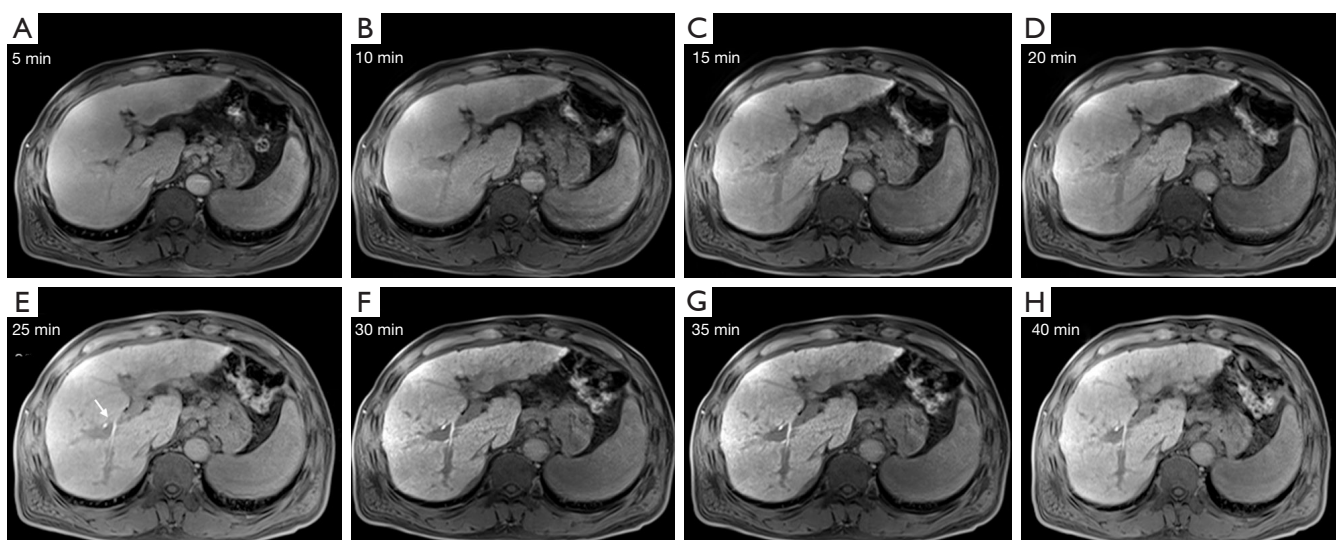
A male cirrhosis patient (CP B), 60 years old, with eight phases of the HCP imaged from 5 to 40 min (A-H) after the administration of the Gd-EOB-DTPA. Two radiologists with 8 and 10 years of experience in abdominal MRI diagnosis identified 25 min (E) as the initial intrahepatic bile duct visualization (white arrow) and so 30 min (F) as the HCP_{proposed}. Two months later, the same two radiologists identified 30 min (F) and 35 min (G) as the HCP_{EC}, respectively, then the third radiologist arbitrated the HCP at 35 min as the HCP_{EC}. CP, Child-Pugh; HCP, hepatocyte phase; Gd-EOB-DTPA, gadoteric acid disodium; MRI, magnetic resonance imaging; HCP_{proposed}, the HCP acquired 5 min after the initial visualization of the intrahepatic bile ducts; HCP_{EC}, adequate HCP determined upon the 2016 Expert Consensus of the European Society of Gastrointestinal and Abdominal Radiology.
